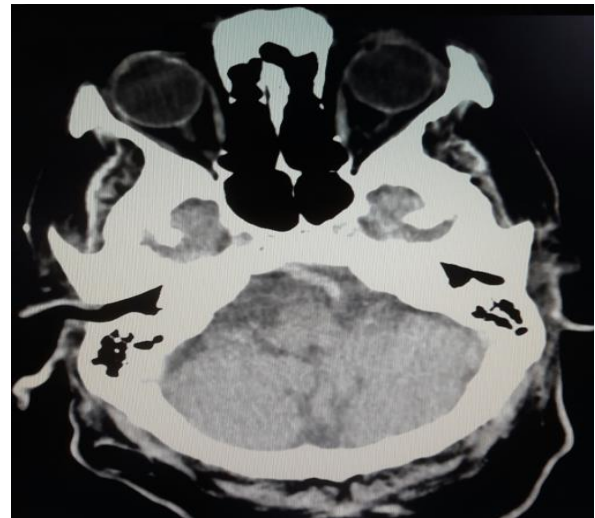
CT scan (in 2020) for the brain which shows the calcified basilar artery (brain window).
